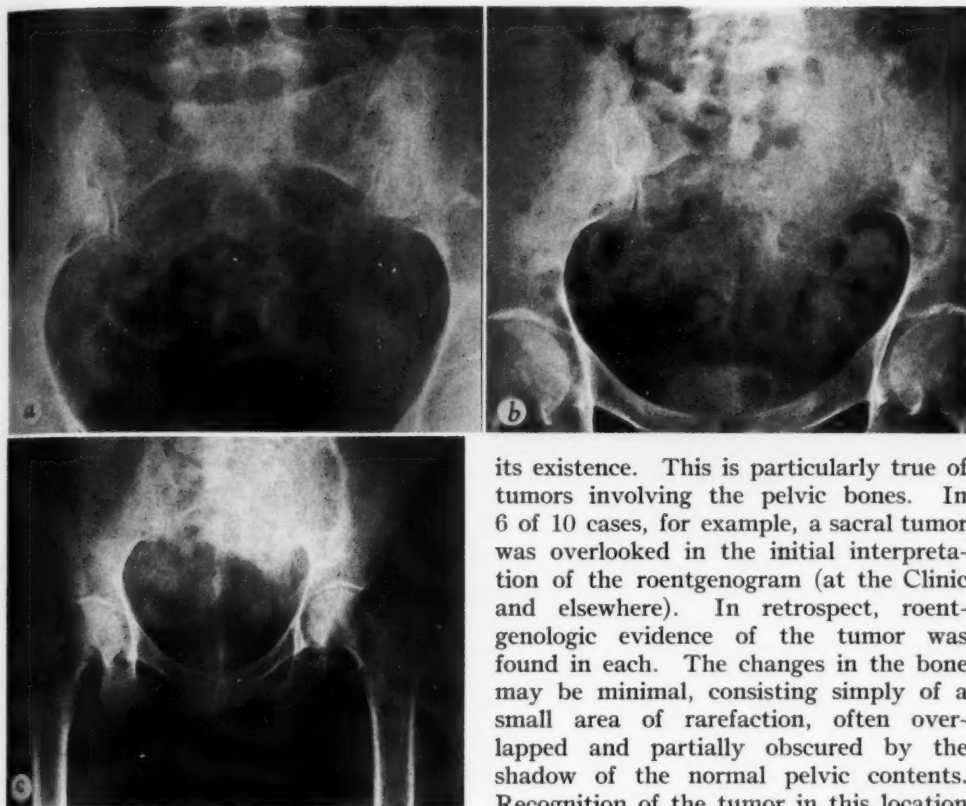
a.* The rarefaction of the lateral masses of the first and second sacral segments on the left was overlooked in the original interpretation of the roentgenograms of the lumbar vertebrae. The lesion was first detected at operation, which was performed at that time.
